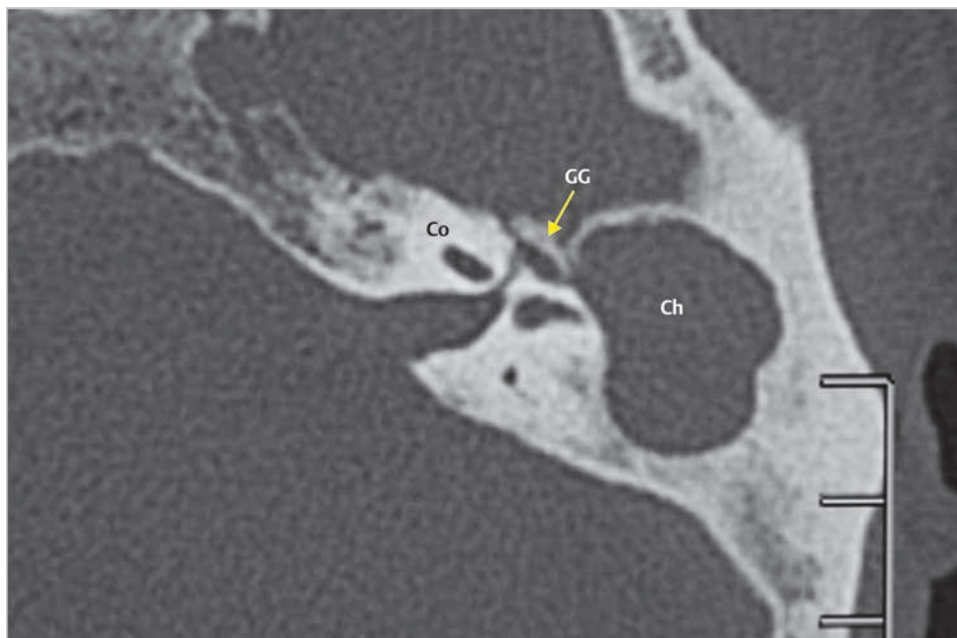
A case of recurrent cholesteatoma in the open cavity is shown. The axial CT at the level of the geniculate ganglion shows round-shaped soft tissue density with expansive bone erosion in the middle ear. Ch, cholesteatoma; Co, cochlea; GG, geniculate ganglion.
